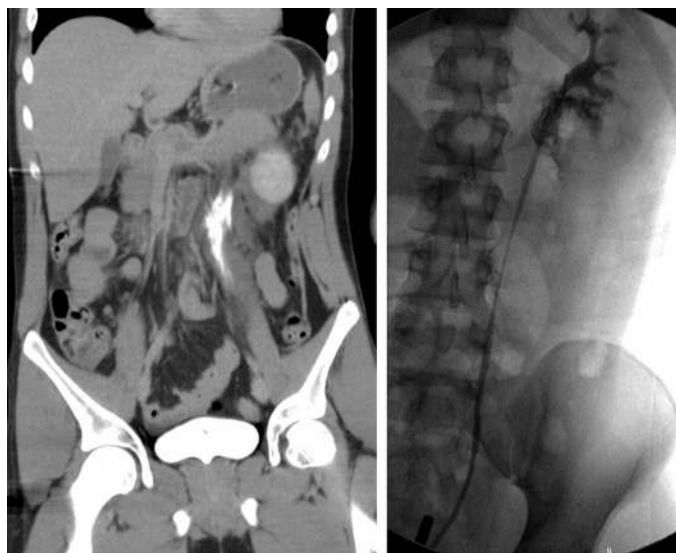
Left-sided ureteral injury: abdominal CT (excretion phase) and retrograde pyelography after fall from great height. Additional injury were a ruptured spleen and grade IV kidney injury. With kind permission (left figure), Prof. Dr. K. Bohndorf, Augsburg.
